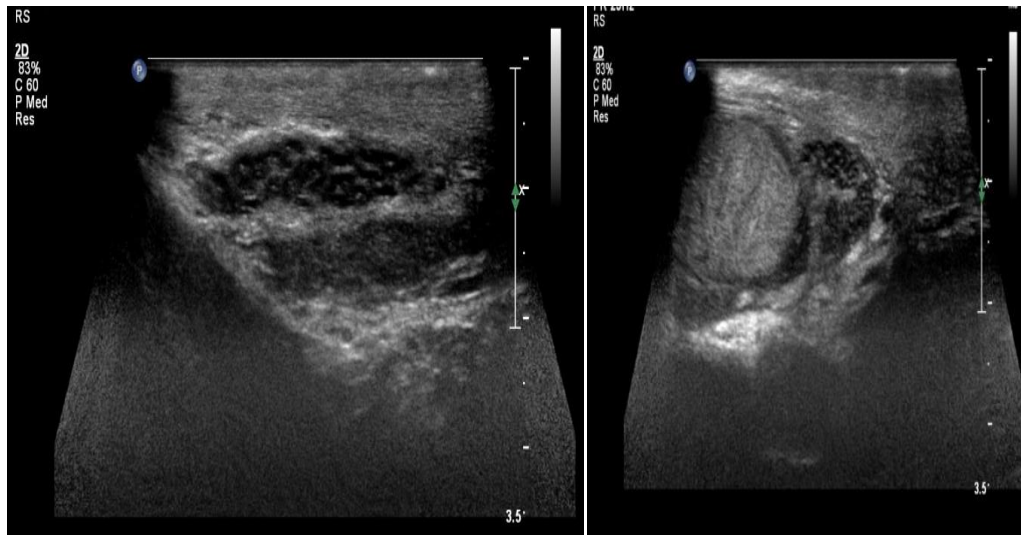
Testicular torsion: upside down testis which shows no internal vascularity within with coiled up spermatic cord appearing echogenic and shows typical “whirlpool” appearance on color Doppler.
